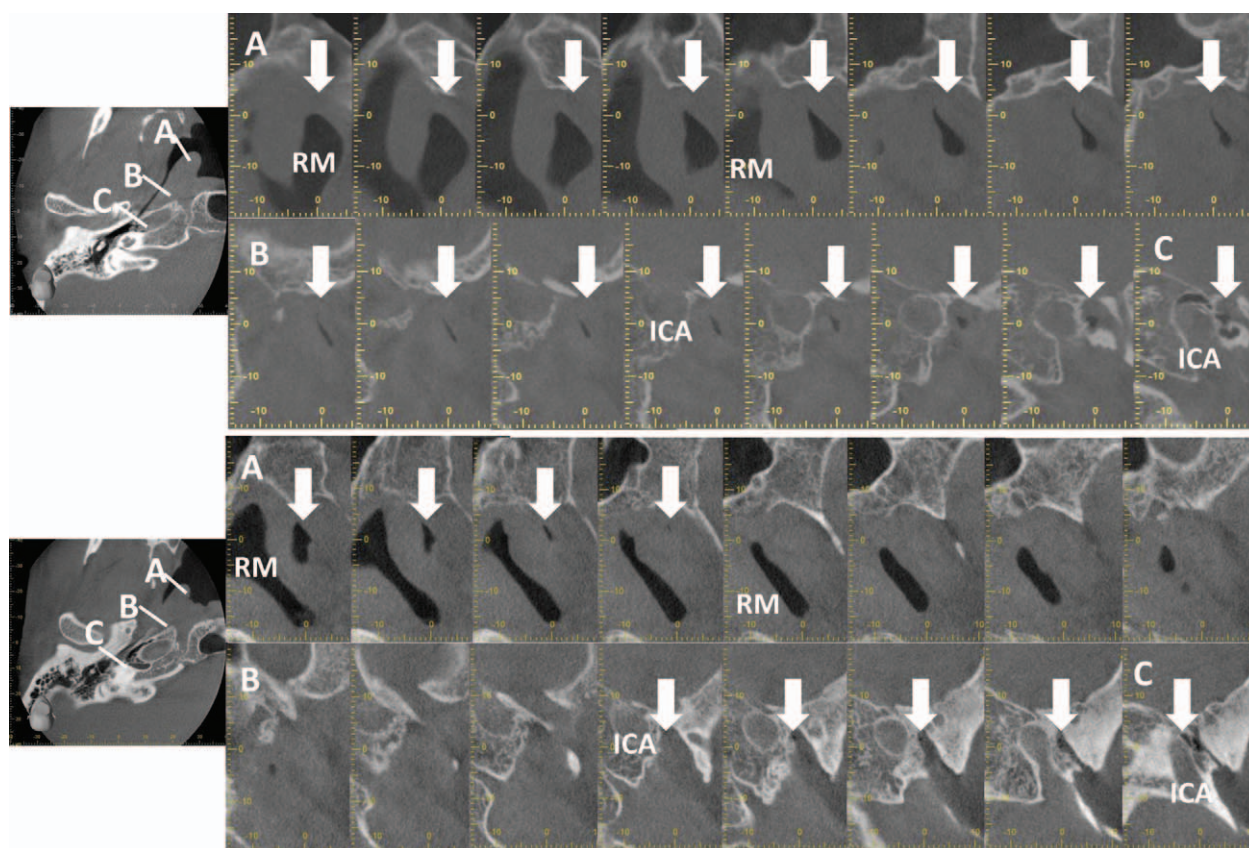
Typical CT images in a patient (*upper row*) with PET showing the ET lumen (*white arrows*), which can be traced from the pharyngeal orifice to the tympanic orifice. Whereas in a normal subject (*lower row*), hyperlucency indicative of the lumen is interrupted at the cartilaginous portion of the ET. The hyperlucency (*white arrows*) indicative of air is detected along the ET. (A, pharyngeal orifice; B, cartilaginous portion; C, bony portion). CT indicates computed tomography; ET, Eustachian tube; ICA, internal carotid artery; PET, patulous Eustachian tube; RM, Rosenmuller recess.
